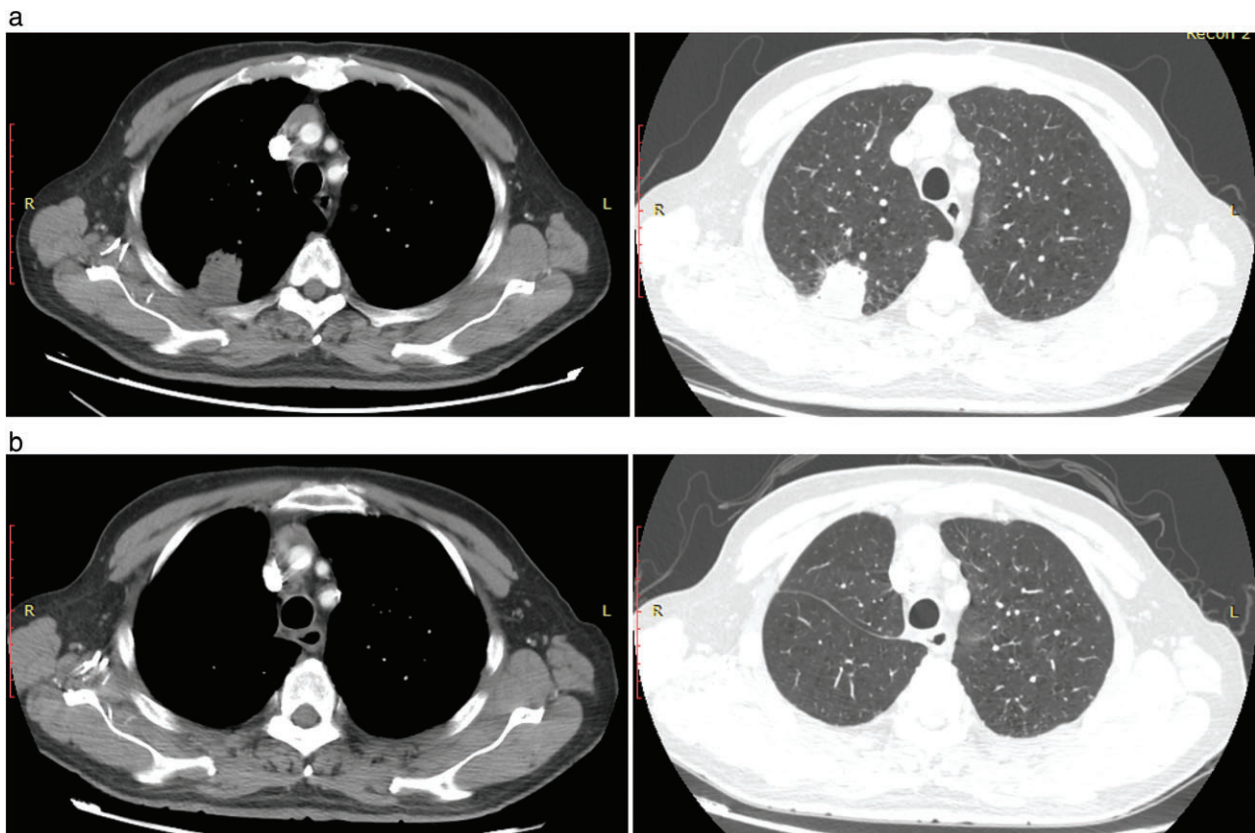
Chest computed tomography (CT) scans. (a) Enhanced CT shows a solitary mass with heterogeneous enhancement in the apico-posterior segment of the upper lobe of the right lung, approximately 3.5 × 3.4 × 2.7 cm in size. (b) CT taken two months postoperatively shows good recovery.
